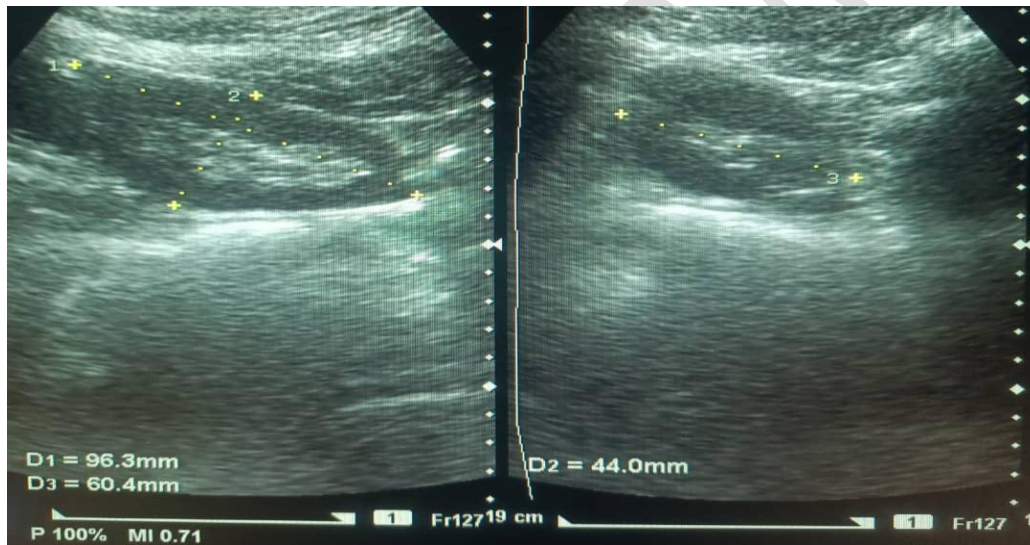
Sonogram showing renal dimensions.
